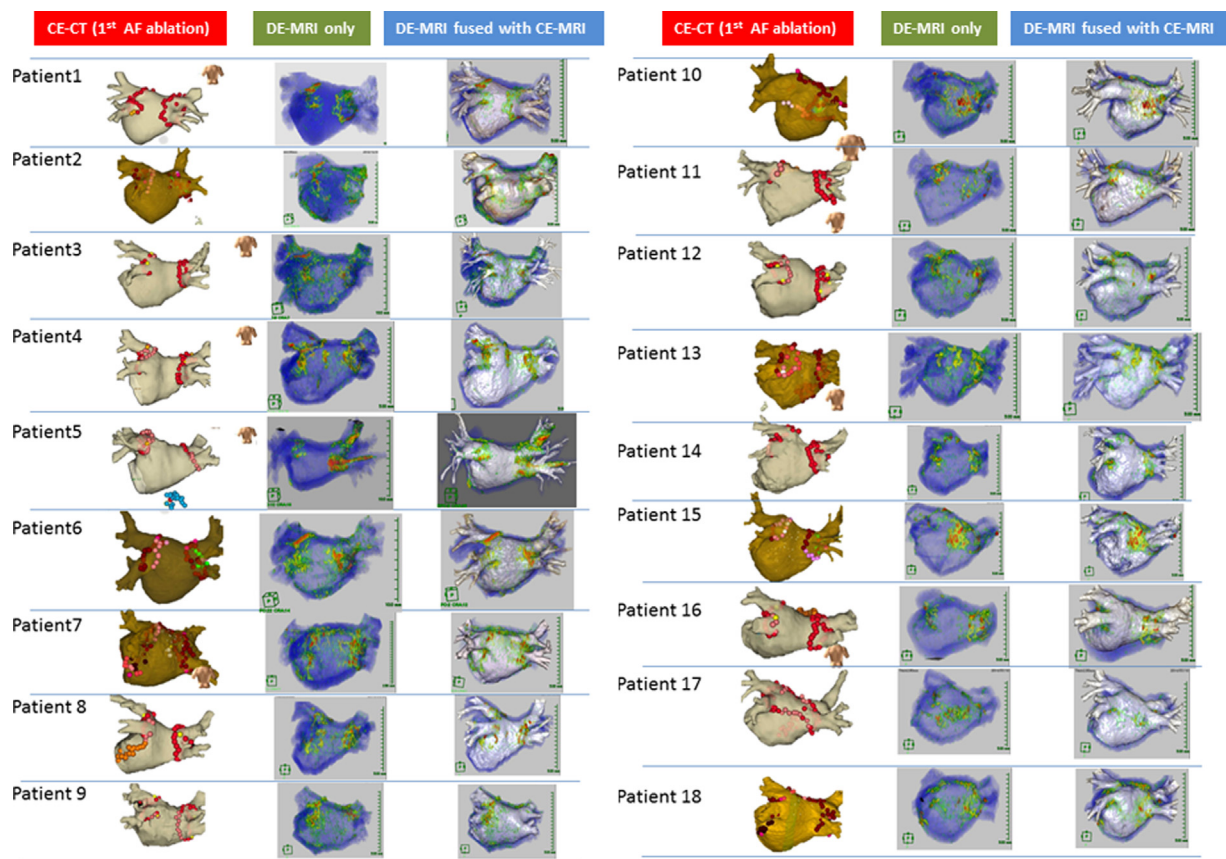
Visualization of RF lesion using DE-MRI and DE-MRI fused with CE-MRA. Catheter ablation using NavX system or CARTO3 system integrated with 3D-CT in the 1st session. The 3D red tag indicates the ablation point. The 3D pink tag indicates the ablation point with a reduced power due to the esophageal temperature rise (left panel). Visualization of RF lesion using DE-MRI (middle panel). Visualization of RF lesion using DE-MRI fused with CE-MRA (right panel). RF=radio frequency; DE-MRI=delayed enhancement magnetic resonance imaging; CE-MRA=contrast-enhanced MRA.
